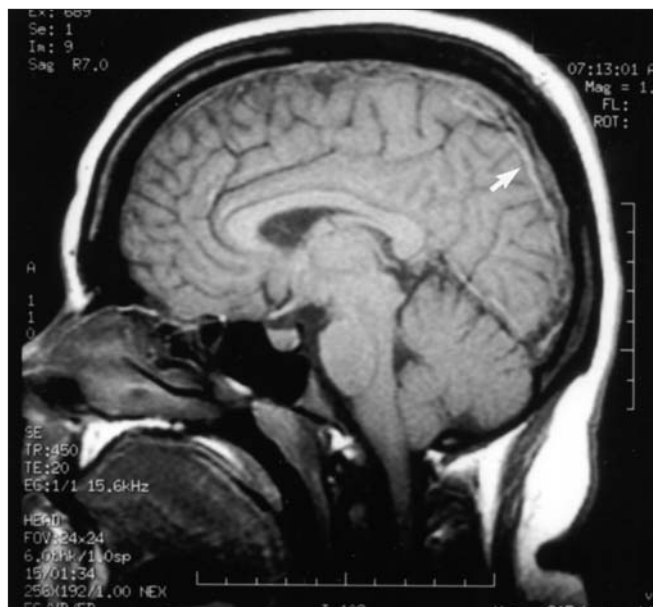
Sagittal magnetic resonance imaging study showing clot within the sagittal sinus (arrow).
